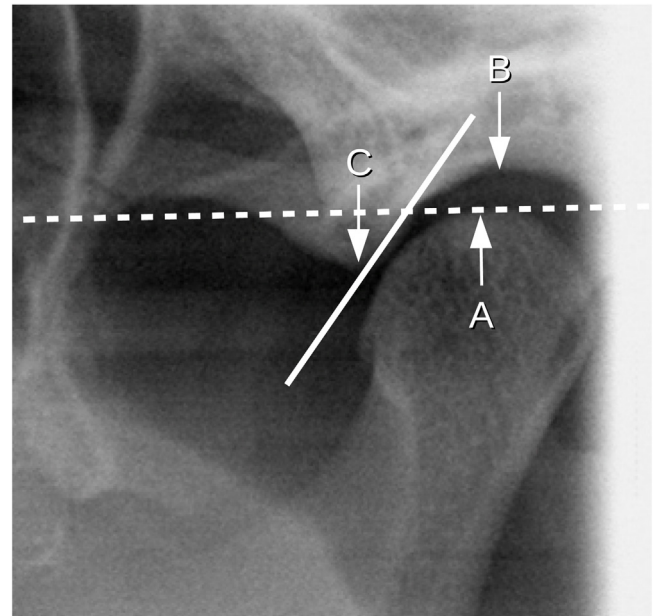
Details of the left jaw joint in an orthopantomogram. (A) Superior-most point of the mandibular condyle. (B) Superior-most point of the mandibular fossa. (C) Inferior-most point of the apex of the articular tubercle. Dashed line: line connecting the superior-most points of both mandibular condyles. Solid line: tangent the posterior slope of the articular tubercle.
